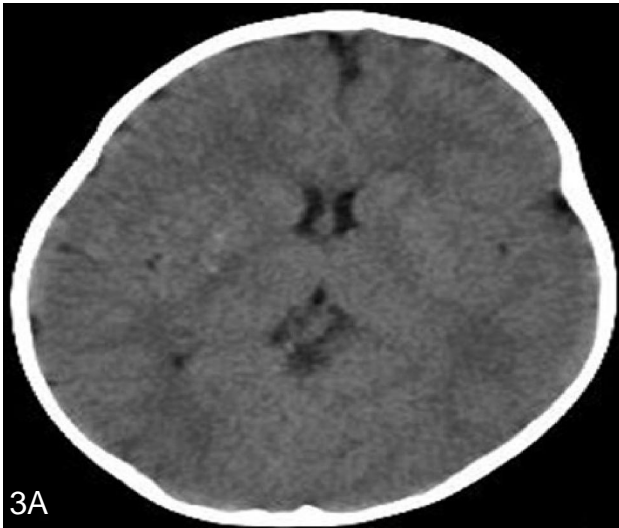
Axial plain CT shows hypodense area of non-hemorrhagic infarct in dorsal portion in right lentiform nucleus and adjoining posterior limb of internal capsule and multiple punctate areas of calcific foci in bilateral basal ganglia.
